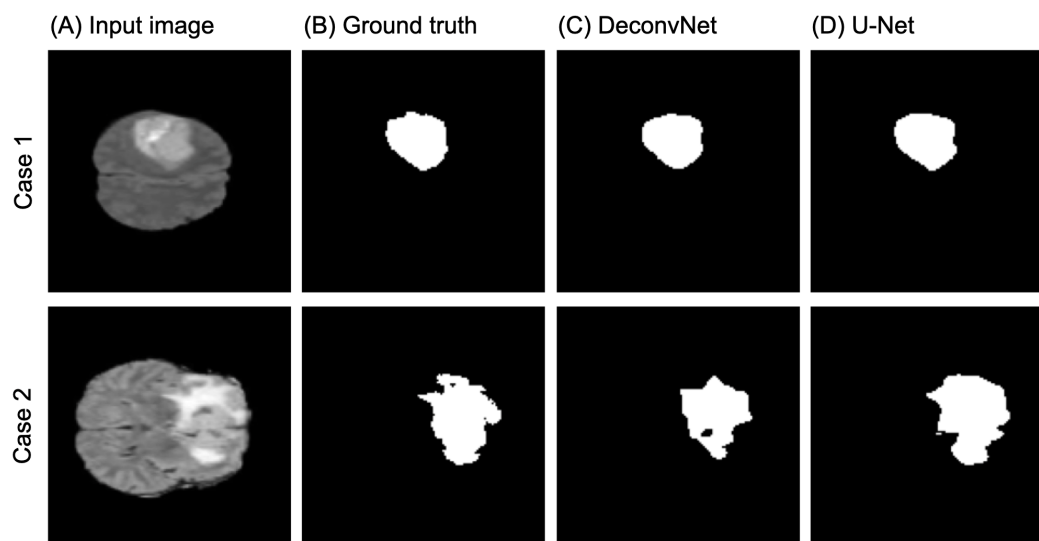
Segmentation examples for the DeconvNet and U-Net models. Two examples are provided, with each row consisting of (A) an MRI from a glioma patient, (B) the actual depiction of the mask by an expert radiologist from the BraTS 2018 dataset (10), (C) the mask predicted by the DeconvNet model, and (D) the mask predicted by the U-Net model.
